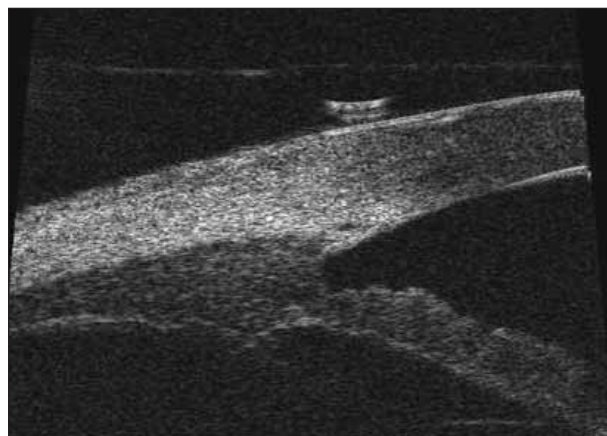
An image of Schlemm’s canal as seen with the iUltrasound 80-MHz-frequency system.
